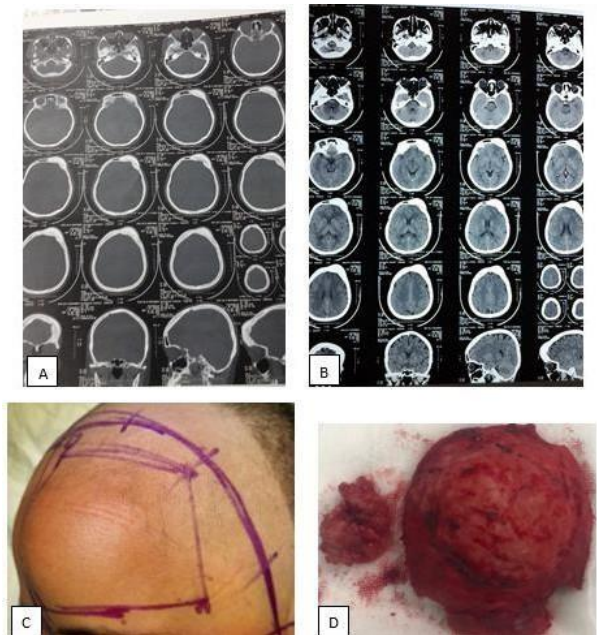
A. CT Scan with Bone Window, B. Non Contrast CT Scan, C. Mass Before Surgery, D. Mass After Surgery
